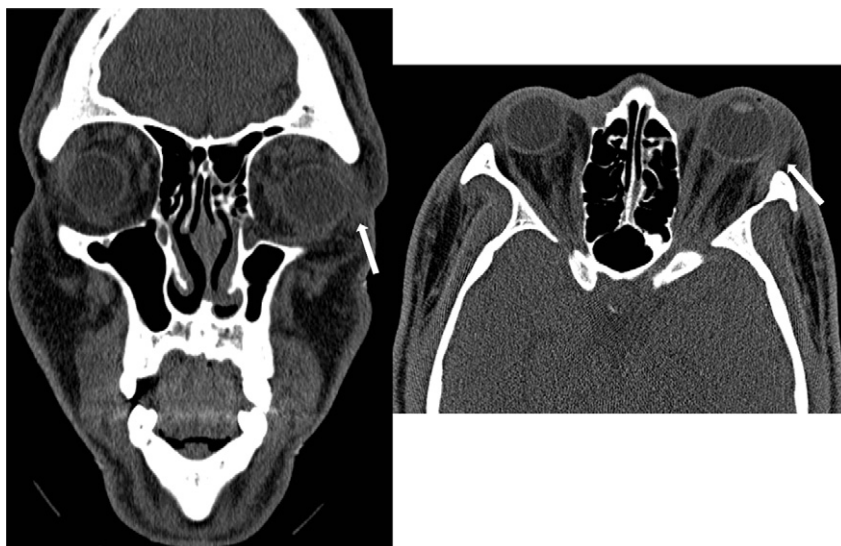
Non-enhanced computed tomography scan demonstrating fat stranding on the pre-septal space of the left orbital region (arrows), suggestive of an infectious or inflammatory process. Bilateral proptosis is also evident.
